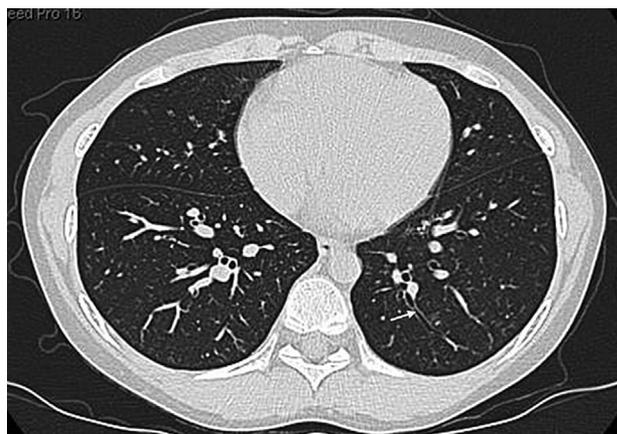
Thin-sectioned axial chest CT image obtained 2 weeks prior to our evaluation reveals areas of cylindrical bronchiectasis (arrow) and bronchial wall thickening in both lower zones and right middle lobe; irregular patchy peripheral reticulonodular densities were also seen in other cuts.
